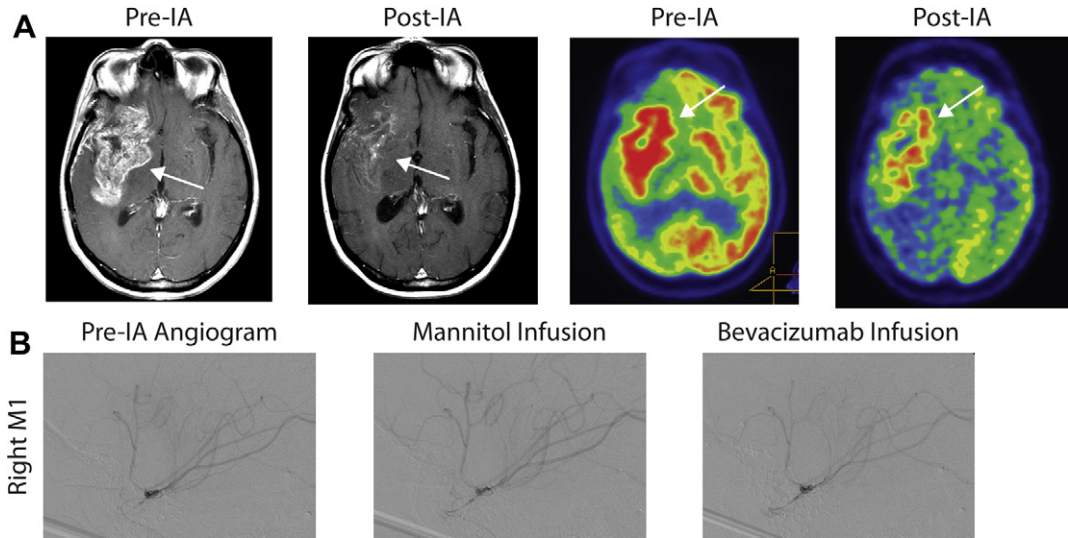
(A) T1 axial magnetic resonance image (MRI) with contrast and fused metabolic positron emission tomography imaging before and 1 month after IA bevacizumab with BBBB treatment. A decrease in the heterogenous enhancement of the right temporofrontal mass on MRI (arrows) and a diminished F-18 fluorodeoxyglucose uptake in the same area are present (arrows). (B) Lateral fluoroscopic imaging of the pre-IA angiogram, after mannitol infusion, and after bevacizumab infusion. The right M1 segment of the right middle cerebral artery was selectively catheterized for infusion of mannitol and bevacizumab to treat the right temporofrontal lesion.
